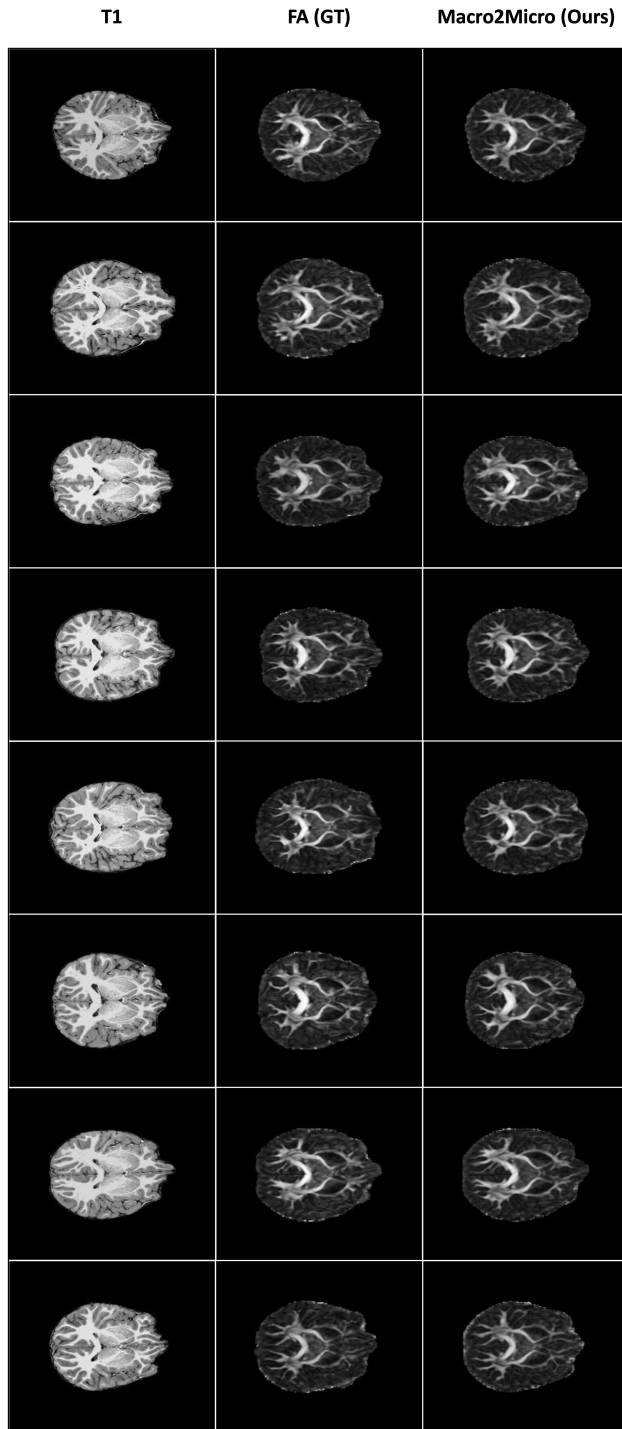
Generated realistic FA images from T1-weighted images using Macro2Micro model.
